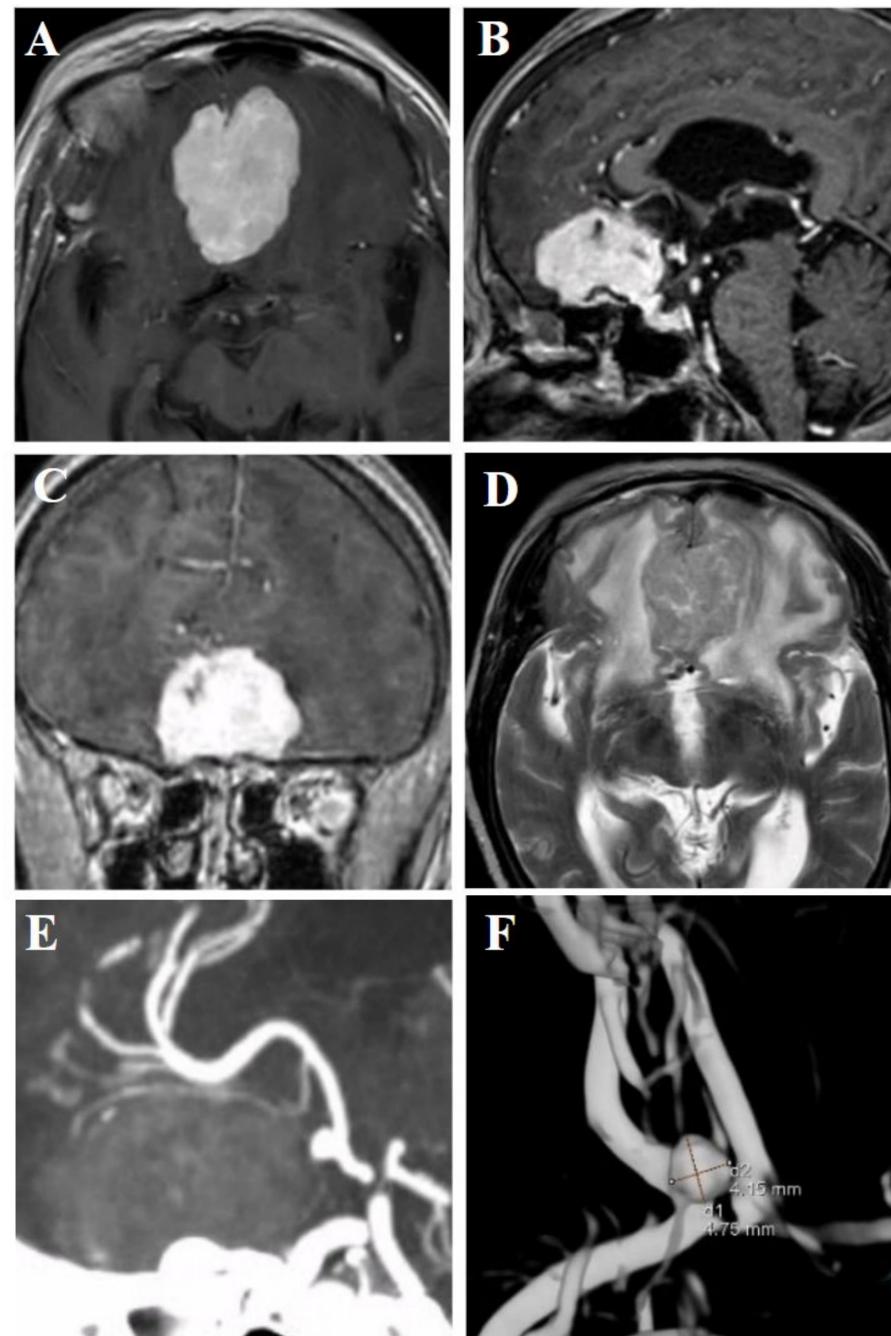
A-D, Brain MRI reveals a large extra-axial, avidly enhancing anterior cranial fossa lesion, consistent with an OGM. Note the substantial vasogenic edema in both frontal lobes. E-F, Head CTA (E) and cerebral DSA (F) show a 5-mm, anteriorly projecting ACoM aneurysm located immediately posterior to the mass lesion. Note the fenestration of the anterior communicating artery on DSA.
